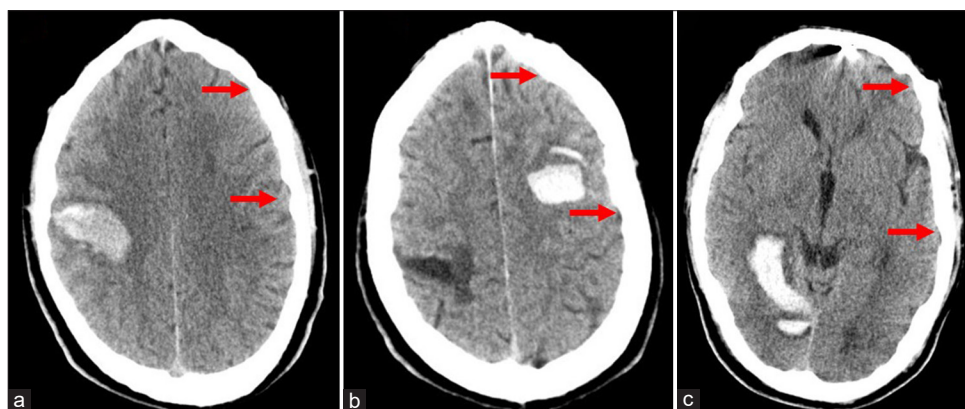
(a) The initial brain computed tomography (CT) showing a large intracerebral hemorrhage (ICH) in the right frontal corticosubcortical area. In the left frontopolar area, an up to 2 cm large area of cortical atrophy and encephalomalacia of the inferior white matter is discernible – a condition after old traumatic brain injury following surgical intervention (arrows). (b) The second bleeding revealed an ICH in the left frontal area. Hypodense area in the right parietal area can be seen – a condition after previous bleeding. (c) The third intracranial bleeding is documented in a CT scan. A large fresh hematoma in the right occipitotemporal area with minimal surrounding edema is present (a-c: arrows).
